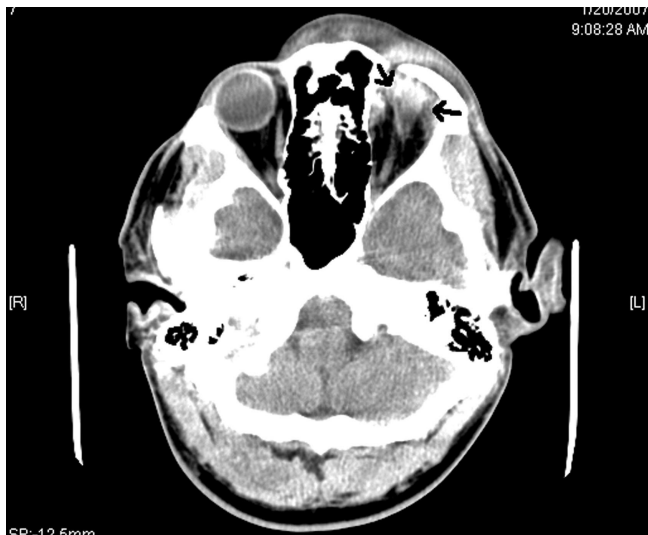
Computed tomography scan of the orbit.
